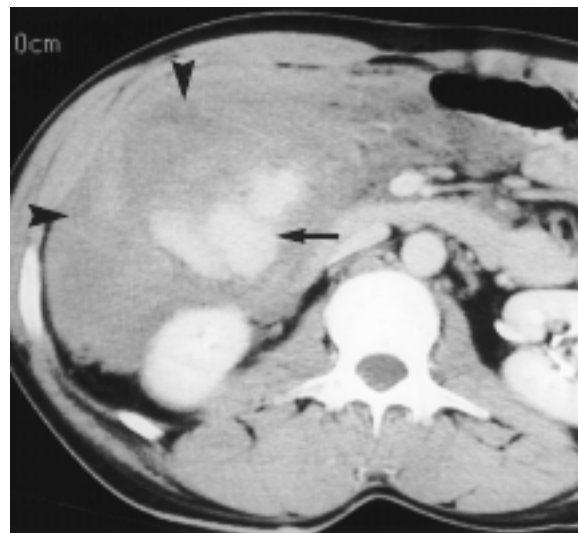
Middle colic artery laceration in a 38-year-old man. CT scan shows a lobulated hyperattenuating area (arrow) that represents extravasation of contrast material within an otherwise nonopacified hematoma (arrowheads).
